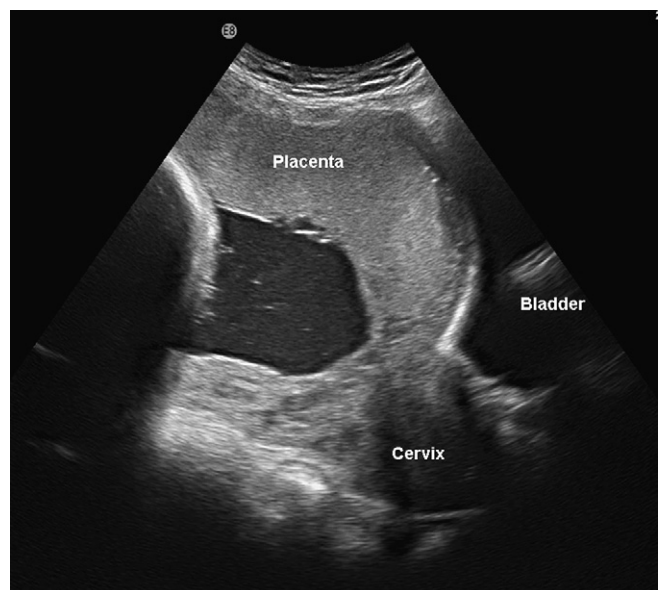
Ultrasound showing the placenta in the lower segment of the uterus and the placental edge encroaching to the internal cervical os.
